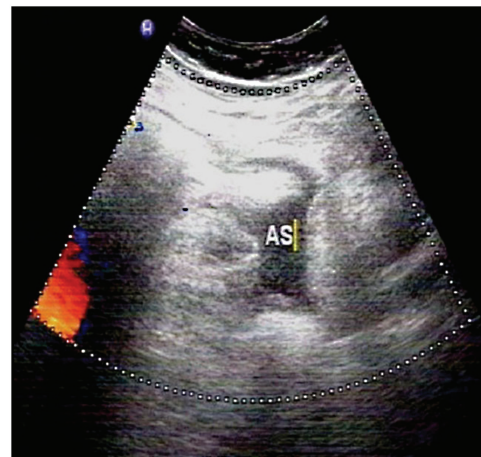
AS shows a large mass within the echogenic bowel and a small number of hypoechoic ascites. AS, abdominal sonogram.
